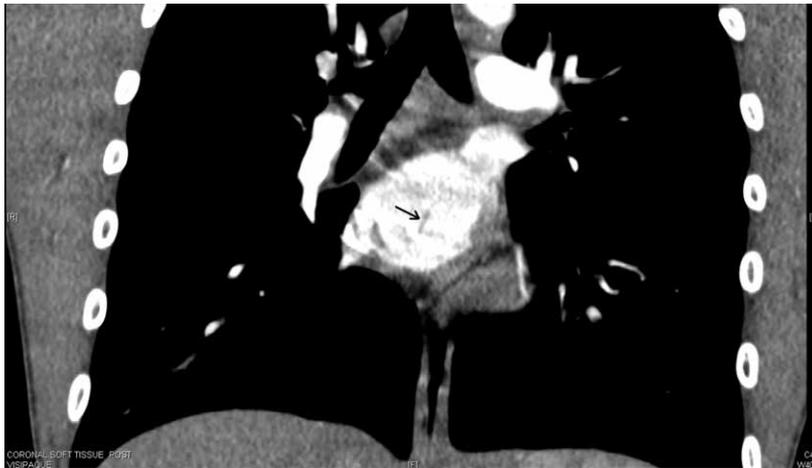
CT angiogram of the chest, postcontrast, demonstrating a non-metallic linear filling defect noted within the left atrium. This filling defect is not visualized on precontrast images, likely corresponding to a foreign body.
